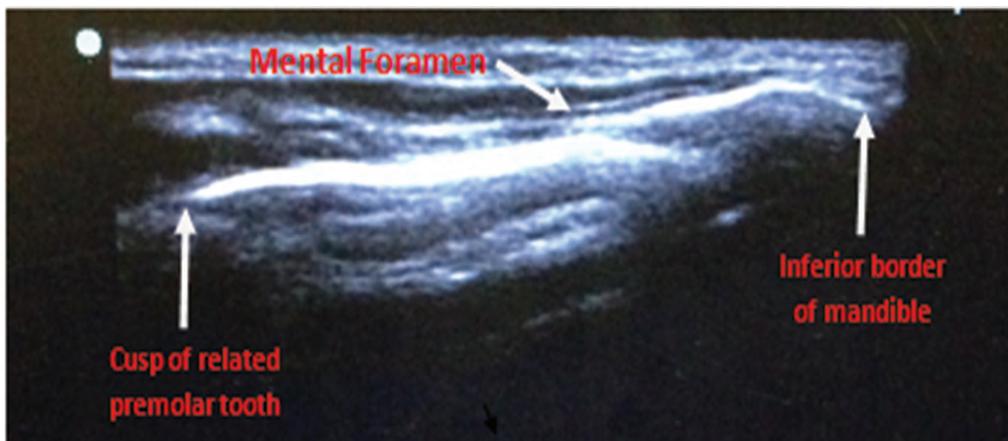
Ultrasound image of the mental foramen and its hard tissue relations. The mental foramen is easily identified as a break in the continuity of the bone in the vicinity just below the corner of the mouth.
